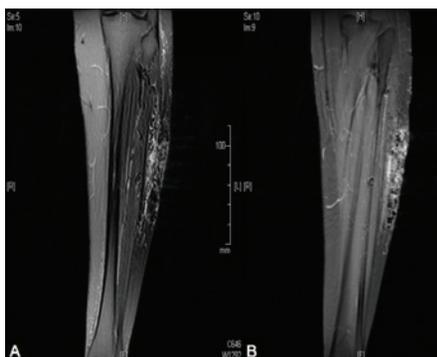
MRI of a left lateral AVM of the calf that has ulcerated to the skin. Patient presented with pain and bleeding.
